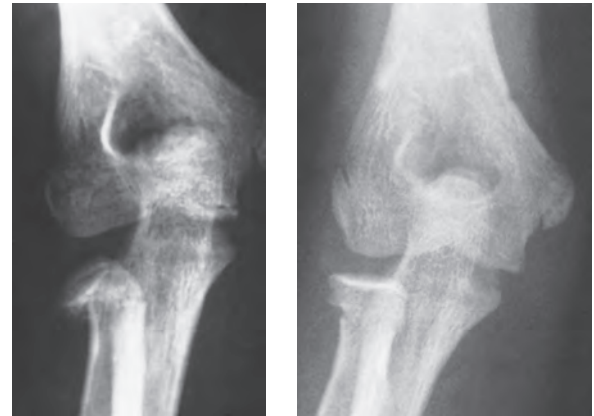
Flexion-pronation (Israeli) reduction technique.⁴⁷ A: Radiograph of the best reduction obtained by the Patterson⁷⁴ method. B: Position of the radial head after the flexion-pronation method. (Courtesy of Gerald R. Williams, MD.)
